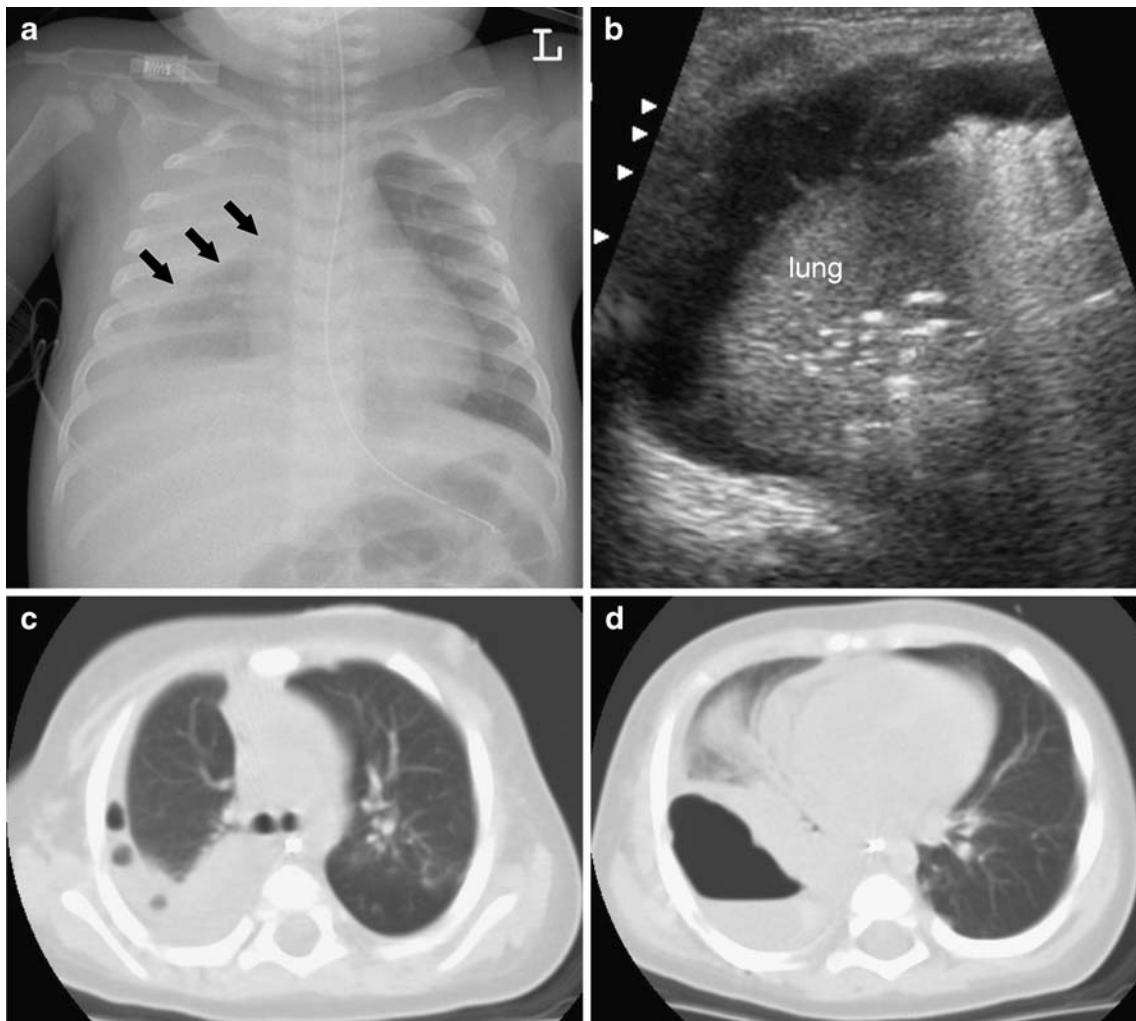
Empyema, role of cross-sectional imaging. Radiograph in 7-month-old girl with pneumonia demonstrates right pleural thickening, which has a convex margin toward the lung (a, *arrow*). Transverse US image of the right chest (b) shows an echo-complex pleural effusion, containing thin septations. CT confirms the presence of loculated
